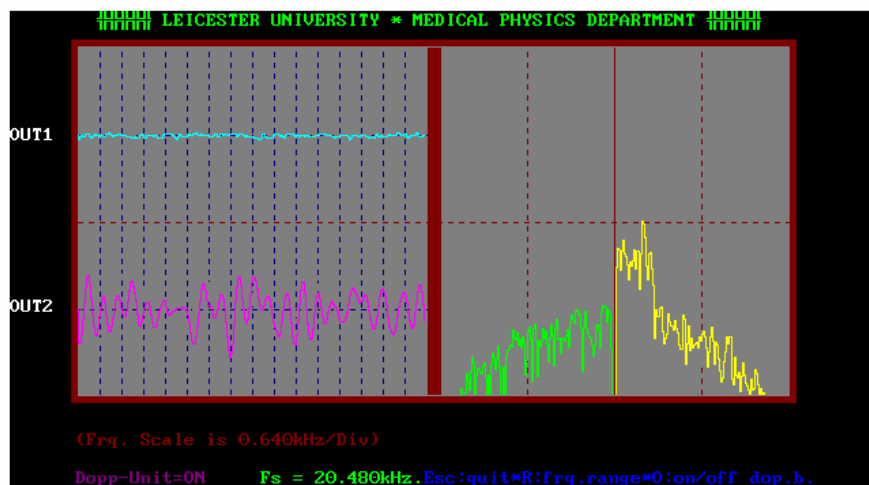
An example of the separated time domain Doppler signals and logarithmic spectral display.
